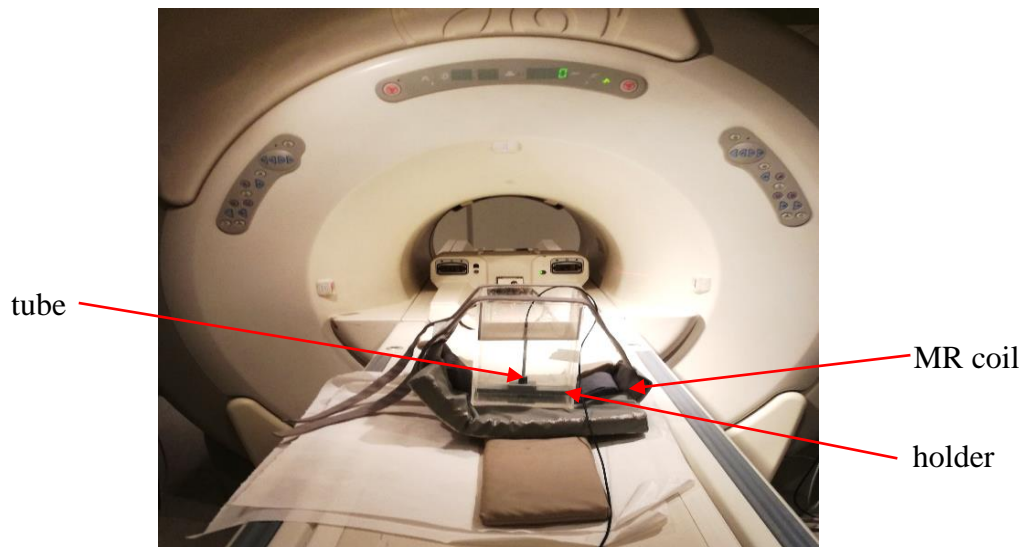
Experimental setup in the MRI room.
